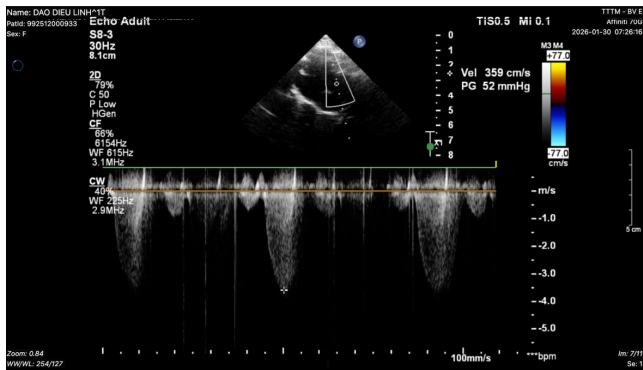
Preoperative Doppler echocardiography demonstrating a restrictive ventricular septal defect with a peak pressure gradient of 52 mmHg
